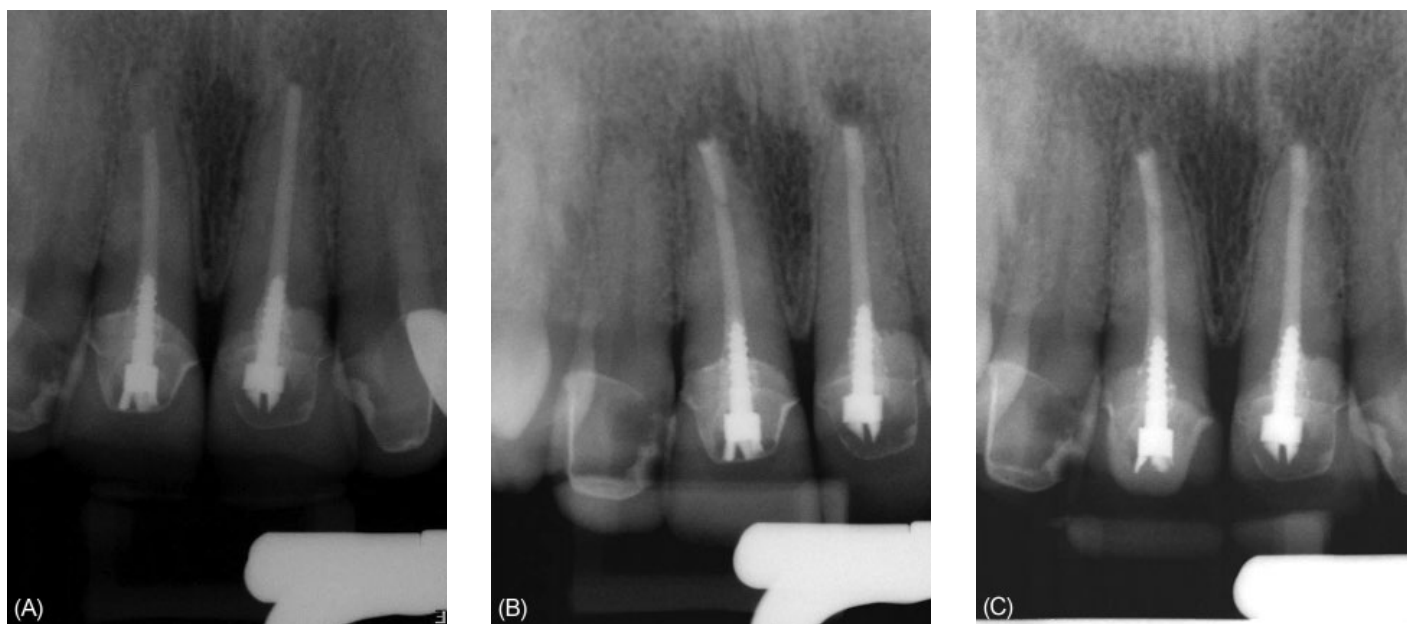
(A) Surgical retreatment of maxillary anterior periapical lesions. Preoperative radiograph. (B) MTA seals of the maxillary central and lateral incisors. (C) Ten-year checkup radiograph shows evidence of bone deposition.
